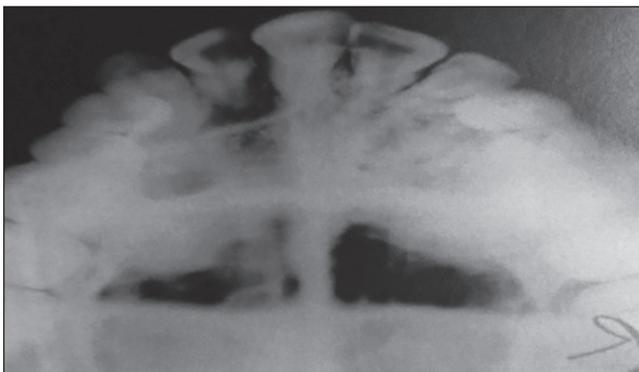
Postoperative radiograph after 6 months showing complete bone formation filling the defect
